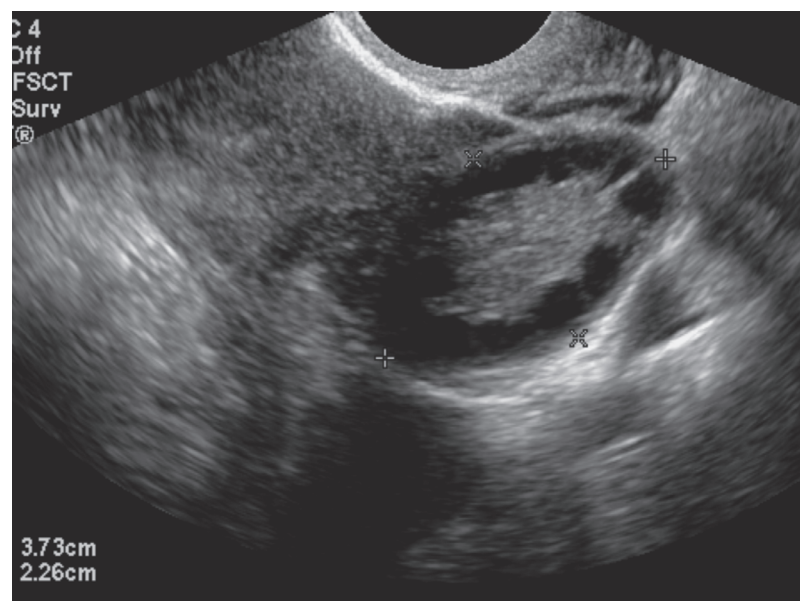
Transvaginal ultrasound showing characteristic polycystic appearance of the ovary. Multiple small dark circles line the periphery of the ovary.
